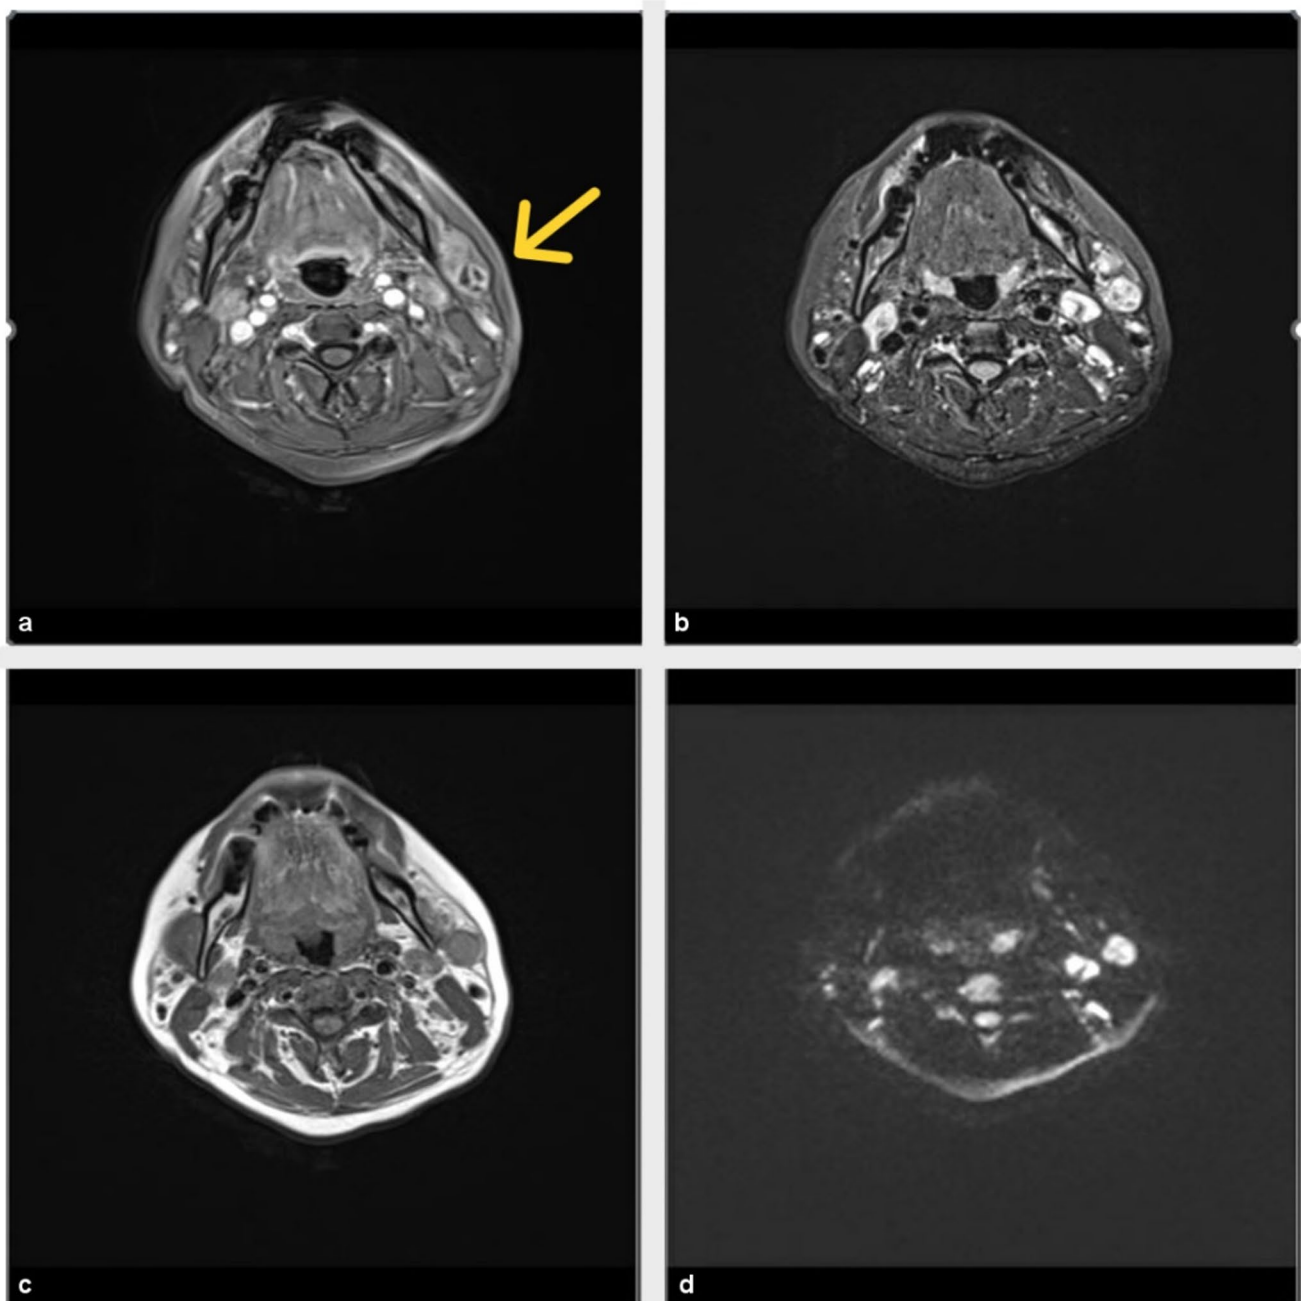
Maxillofacial MRI image showing rounded intraparotid lesion with enhancement and cystic-necrotic content in T1 fat-sat (a), STIR (b) and standard T1 (c) sequences. Marked restriction is also observed in diffusion sequence (d)
